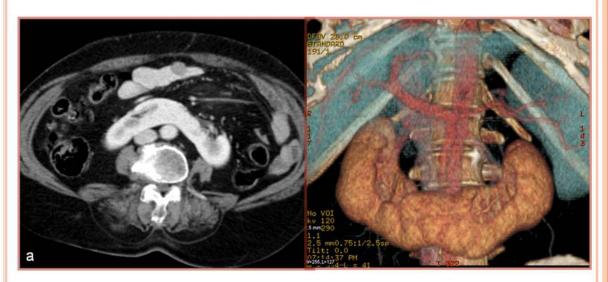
a, b. Axial CT (a) and coronal volume rendering (b) images show horseshoe kidneys that are fused with functioning renal parenchyma at their lower poles. The isthmus lies anterior to the aorta.
